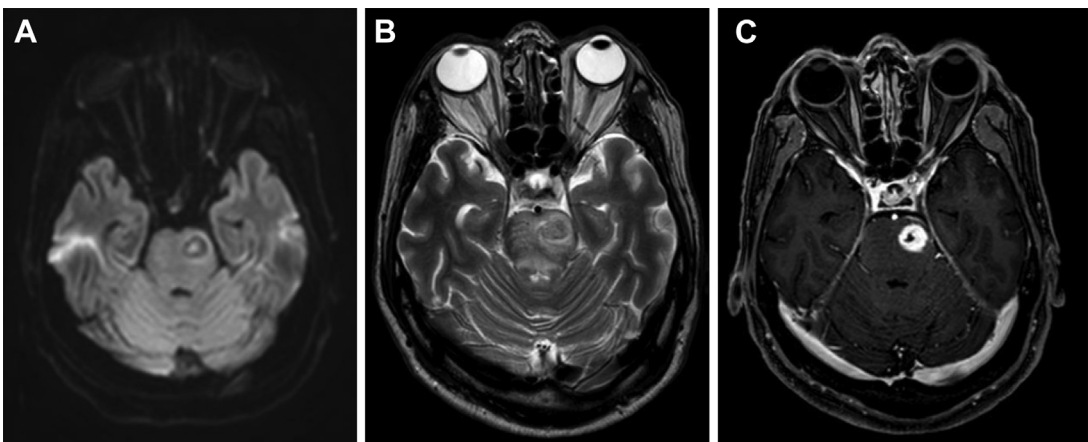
Caseating granuloma with central necrosis. Axial DWI (A) shows a centrally diffusion-restrictive lesion in the left side pons with mixed T2 high signal intensity (B) and irregular thick rim enhancement (C).
